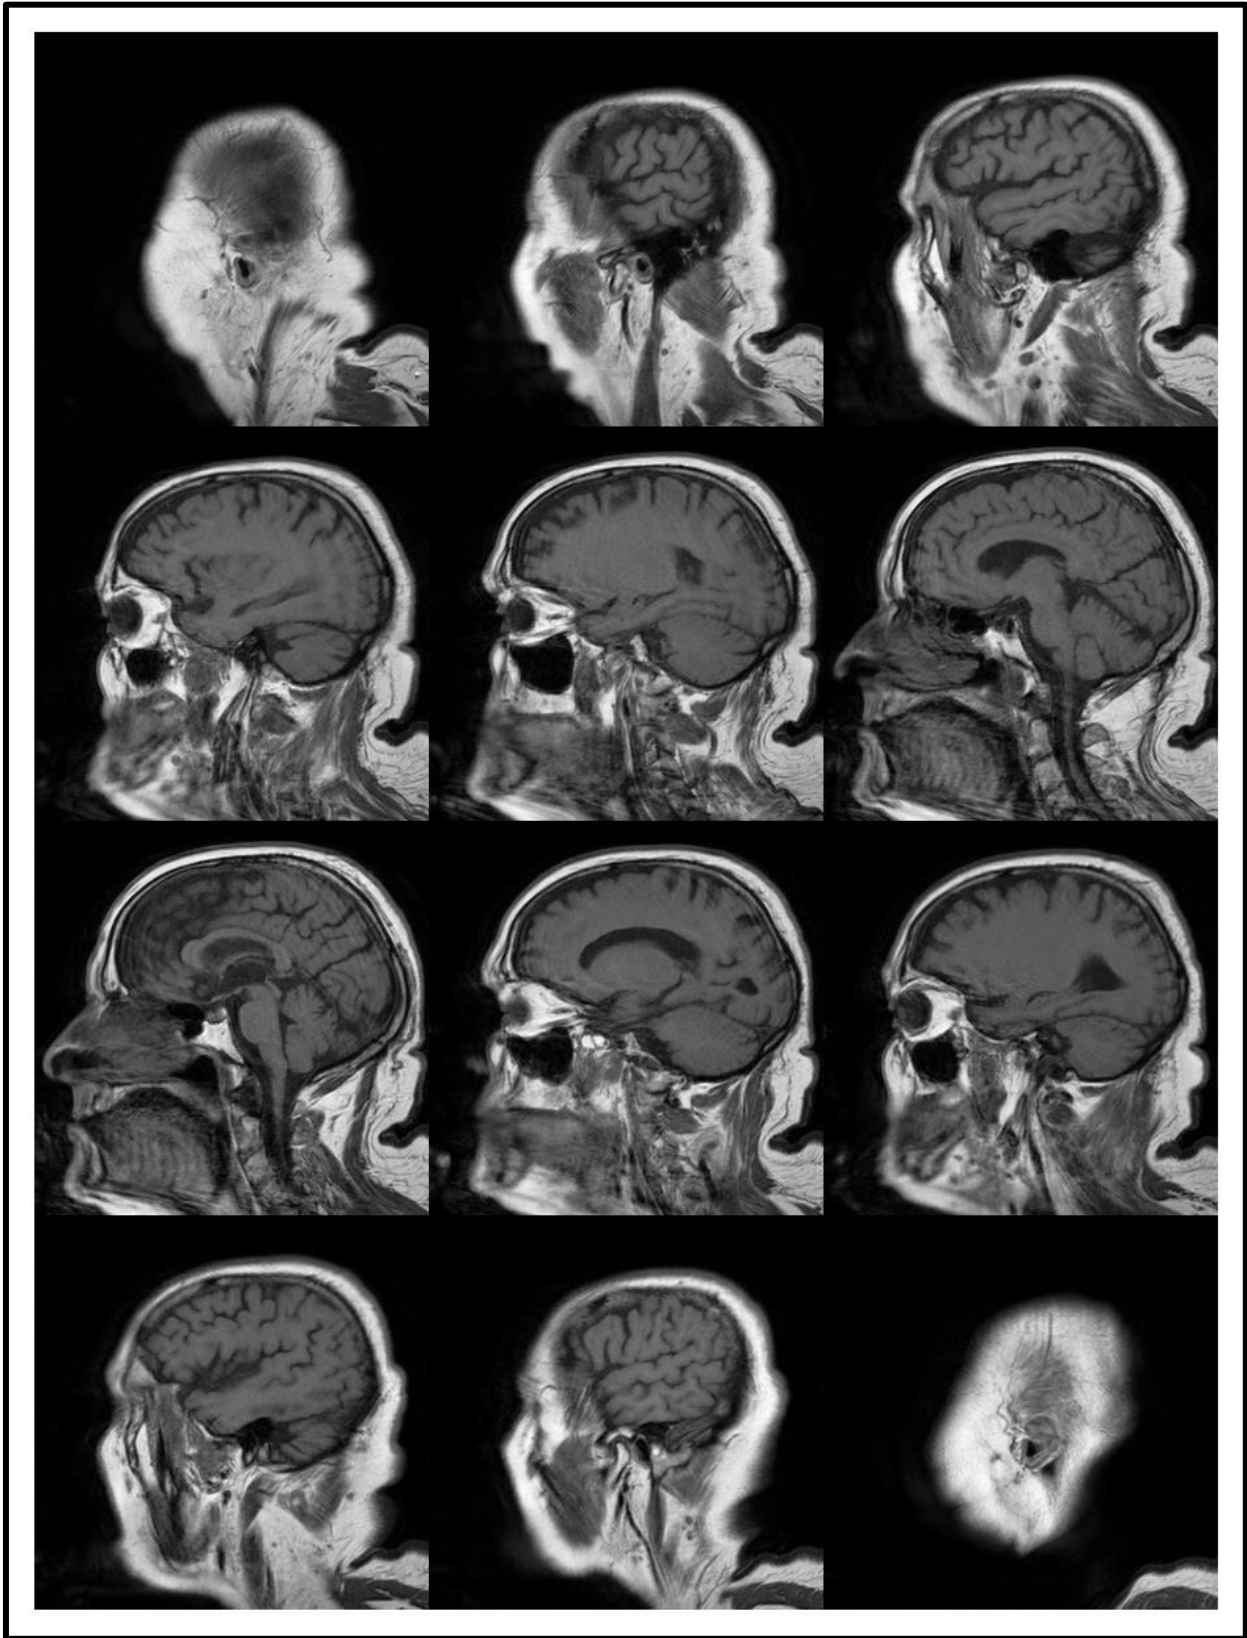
Case 1 MRI Scan Input
